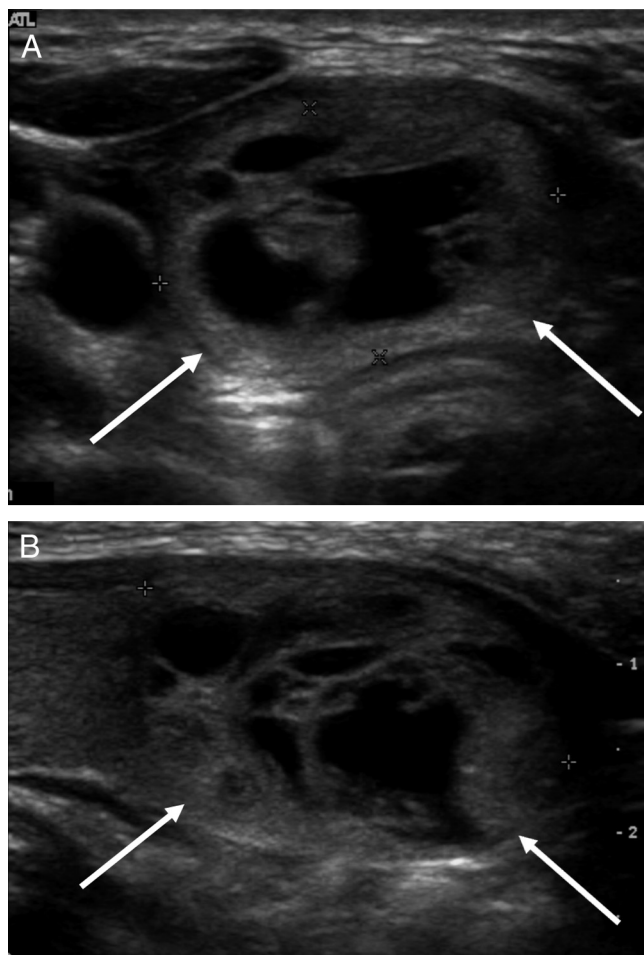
A 21-year-old woman with B-PTC. Transverse (A) and longitudinal (B) ultrasonograms show a 2.7-cm well-defined and isoechoic nodule (arrows) in the right thyroid gland, which was diagnosed as PTC by US-guided FNA. She underwent total thyroidectomy without central LN dissection. A pathologic report revealed a 2.2-cm PTC without extrathyroidal extension.
